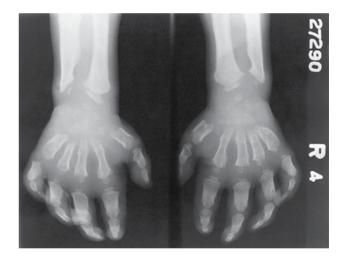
Roentgenogram of the hand of an 11-year-old patient with mucolipidosis type III. The picture was that of an extreme degree of dysostosis multiplex.
